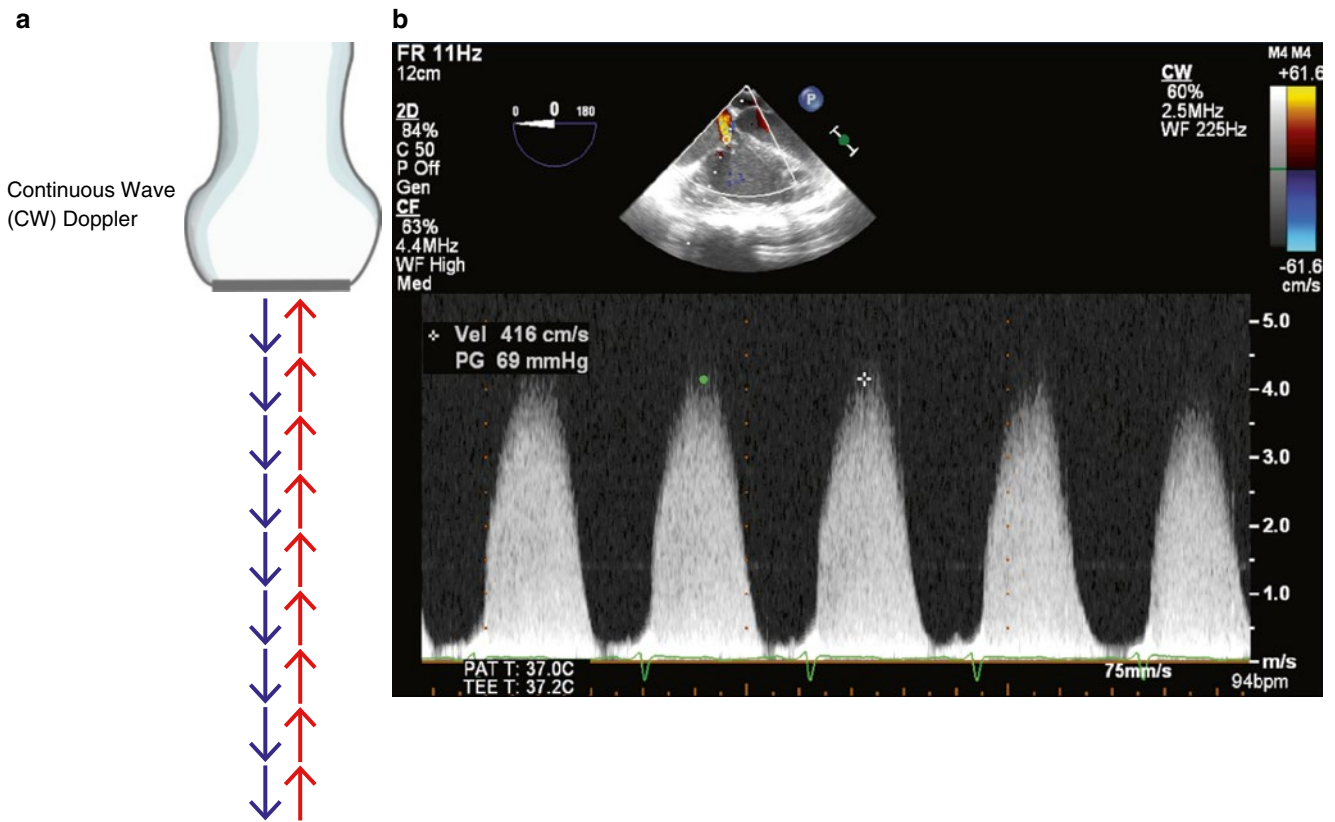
Continuous wave Doppler. There are two basic components: a transmitter that continuously sends sound waves of known frequency, and a separate receiver that continuously receives all returning signals (a). The “difference frequency” is plotted as a function of time, yielding a spectral display with a wide dispersion of frequencies and significant spectral broadening (b). In this example, a high velocity tricuspid
